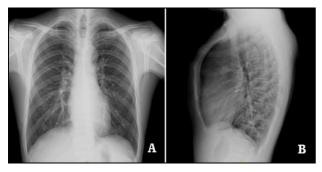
Preoperative chest X-ray examination.
